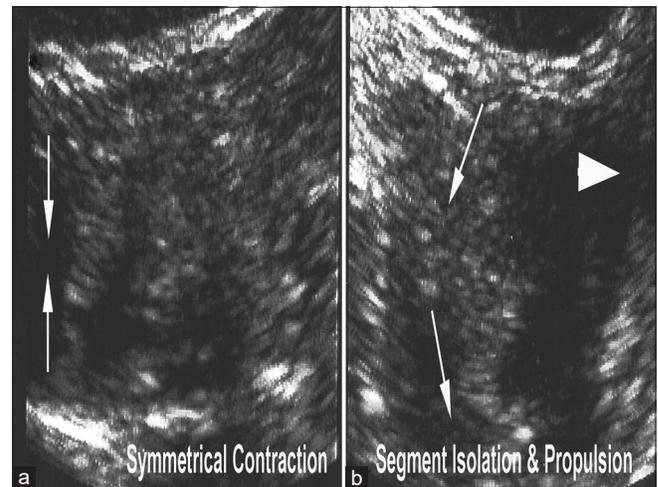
(a and b) Sample sonograms of normal colonic peristalsis showing symmetric contraction (a) and relaxation (b) of the walls
